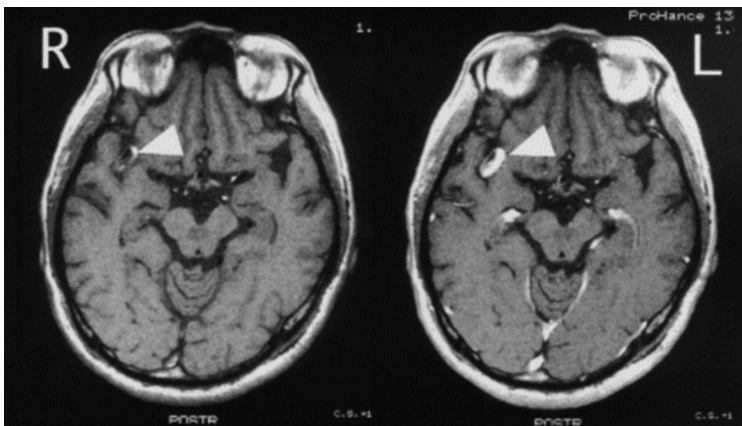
Axial MR image revealing a high-intensity area and crescentic enhancement with contrast medium around a dilated signal void of the right M2 (arrow) (left: T1-weighted image, right: T1-weighted image with contrast medium) [24].
